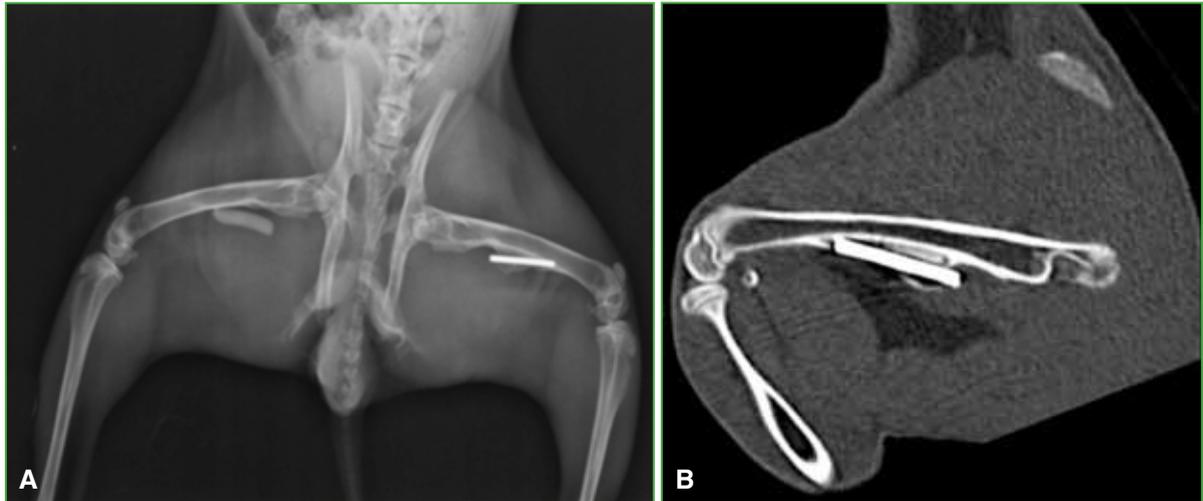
A. X-ray of both femurs. Antibiotic-coated cement spacer placed in the right femur and TEN nail placed in the left femur. B. CT scan. TEN nail.
